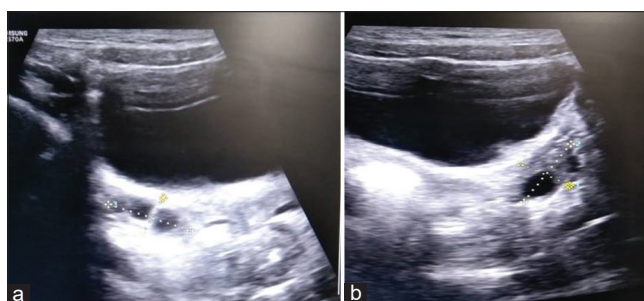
Ultrasound abdomen/pelvis: (a) left ovary and (b) right ovary.
